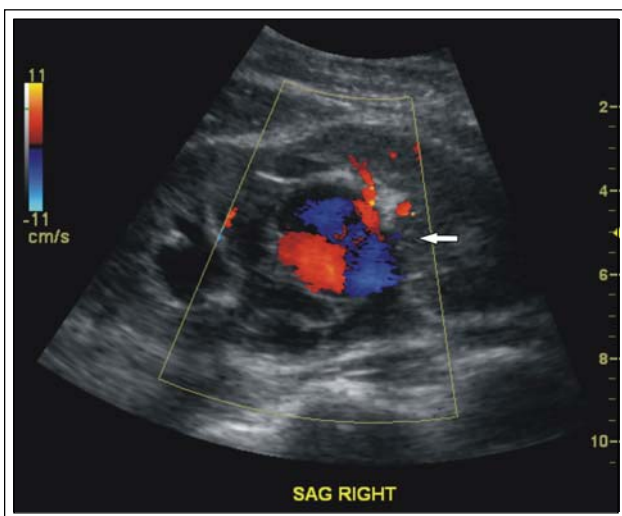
Right renal duplex ultrasonography. White arrow demonstrates characteristic appearance of swirling blood.
